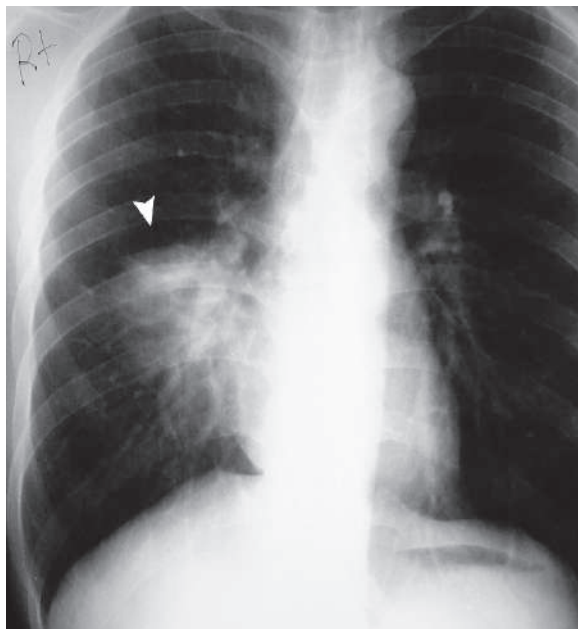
Posteroanterior plain chest radiograph in a patient with primary TB shows a pneumonic patch in the right middle lung zone (arrowhead) with ipsilateral lymphadenopathy
